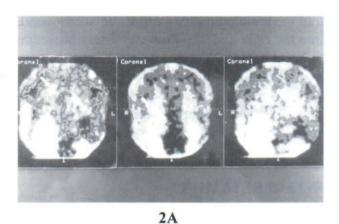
SPECT coronal views of Tc-99m apcitide revealed 3 foci of abnormal uptake at RUL, RLL, LLL (arrows)
